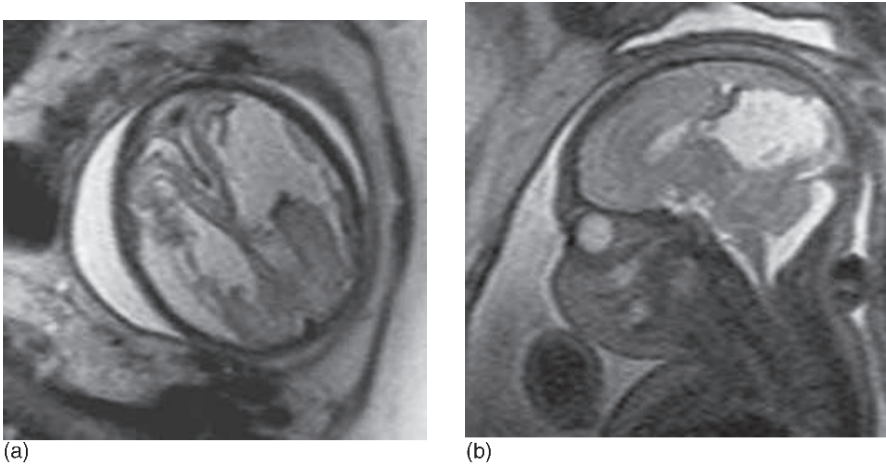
Axial (a) and parasagittal (b) single-shot fast spin echo T2-weighted half-Fourier-acquisition single-shot turbo-spin-echo MRI scan of the brain of a third trimester fetus infected with CMV in the early second trimester shows brain destruction, colpocephaly, and periventricular magnetic susceptibility consistent with calcification (images courtesy of Janet Reid, M.D.; reproduced with permission from: Faerber E. TORCH infections. In: Reid JR, ed. Pediatric radiology curriculum [Internet]. Cleveland, OH: Cleveland Clinic Center for Online Medical Education and Training; 2005. Available from: <https://www.cchs.net/pediatricradiology>).
